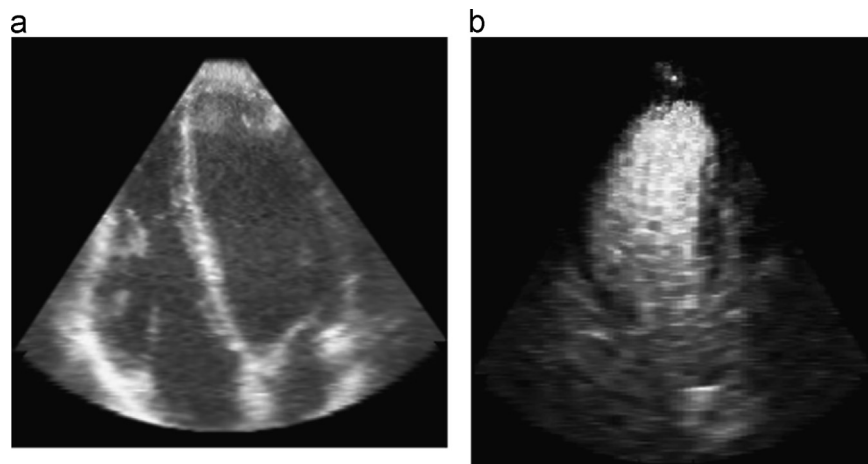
Comparison of image appearance between (a) routine echocardiography and (b) contrast echocardiography. Note the inverted appearance.
